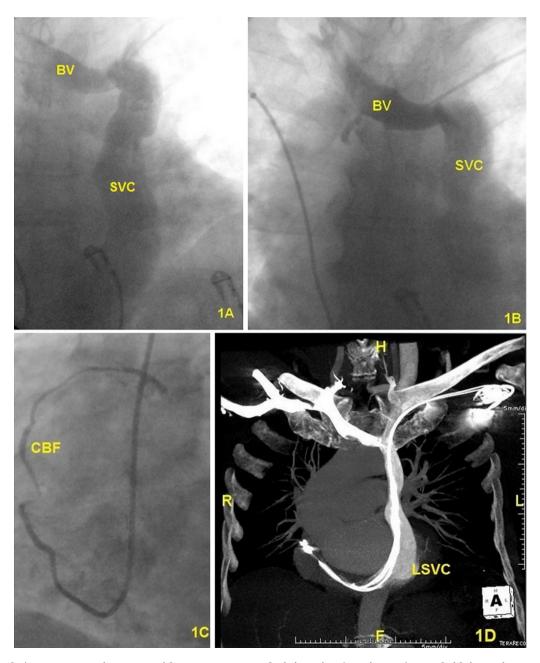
(A and B) Postero-anterior X-ray with contrast agent administration (omnipaque), BV – bridging vein, SVC – superior vena cava; (C) selective coronary angiography showing coronary-bronchial fistula; (D) axial computed tomography scan of sole LSVC – left superior vena cava.
